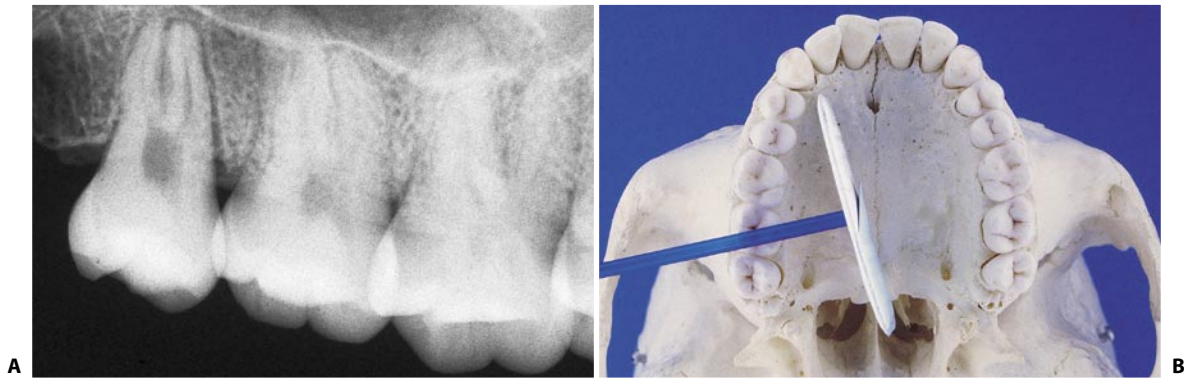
A. Distomesial angulation reveals the mesiobuccal root not superimposed on the palatal root. B. Path of the X-rays in the distomesial projection.
